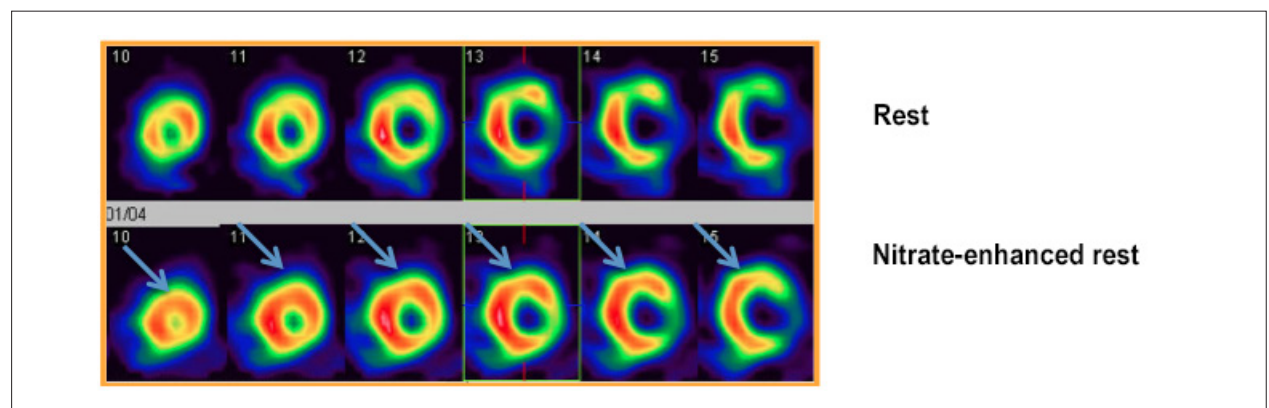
Images of rest (upper line) and nitrate-enhanced rest (lower line) myocardial perfusion scintigraphy, showing improvement of perfusion in anterior (apical, medial and basal) and anterolateral (medial and basal) segments.
